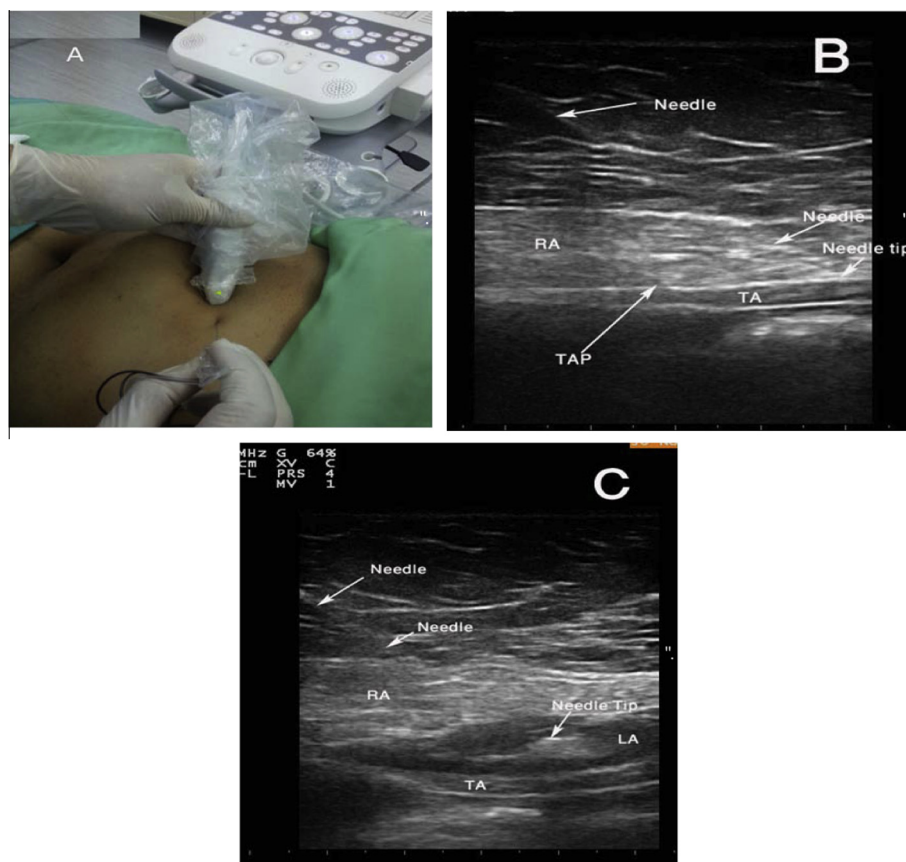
(A) Placement of ultrasound probe for subcostal TAP blocks, (B) ultrasound anatomy and needle placement TAP (transversus abdominis plan) at the fascia layer between TA (transversus abdominis muscle) and RA (rectus abdominis muscle), (C) ultrasound image during injection of local anesthetic.
